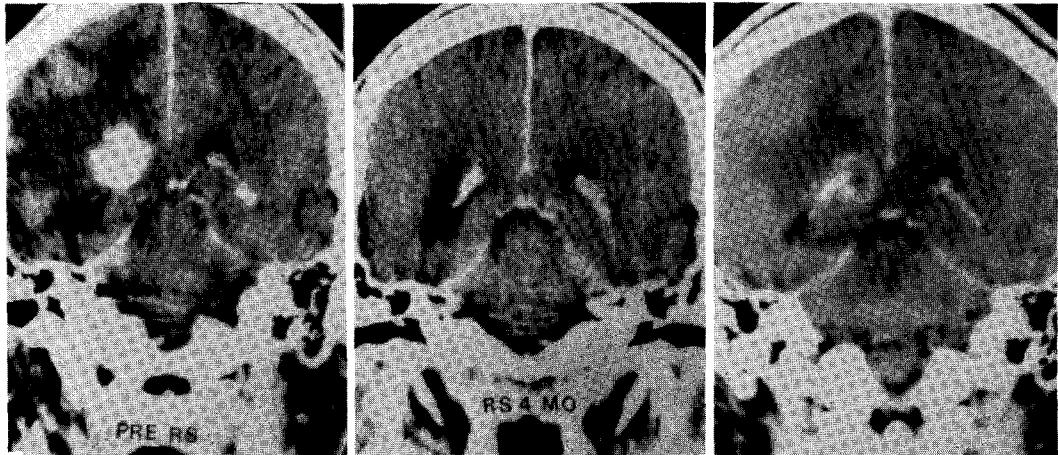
Pre-radiosurgery CT scan revealed well demarcated mass on trigone of right lateral ventricle and surrounding brain edema. RS was done with an impression of choroid plexus papilloma by neuroimage alone (left). Complete disappearance of mass without brain edema on CT Scan at 4 months after RS (middle). CT Scan at 23 months after RS revealed contrast enhancing lesion on previous tumor site with brain edema. This finding should be differentiated between tumor recurrence and brain necrosis (right).
